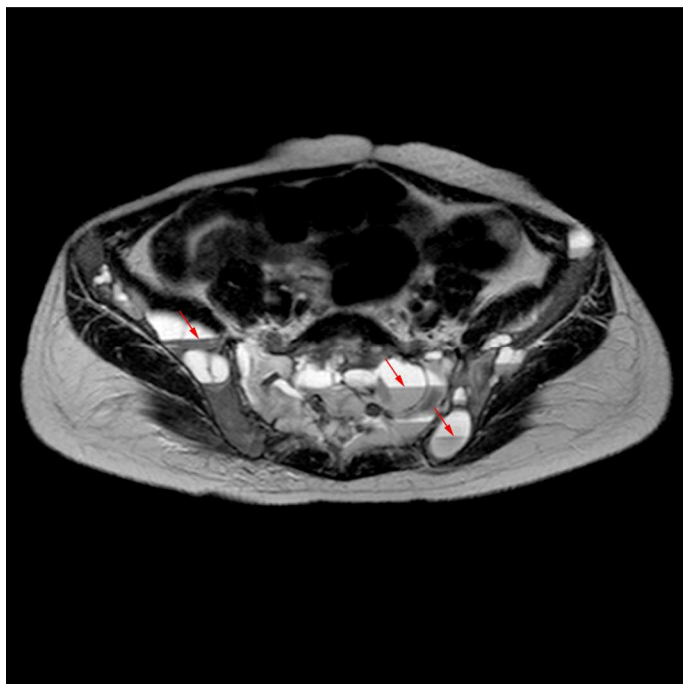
Multiple lytic bone lesions with fluid-fluid levels (arrows) were also evident in this unenhanced axial magnetic resonance image of the pelvis.
